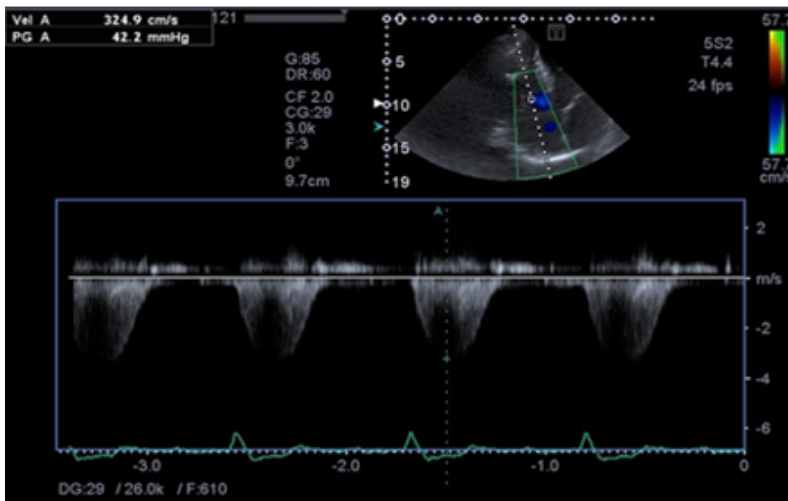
Continuous Doppler (CW). Apical 4 chambers section with the Doppler CW volume sample placed on the tricuspid valves. Record of the tricuspid transvalvular flow with a view of a velocity of 3.24 m / s (high velocity unlike PW), with the possibility of calculating the maximum gradient between RV and RA (in this image with a value of 42.2 mmHg) used in estimating systolic pulmonary arterial pressure
